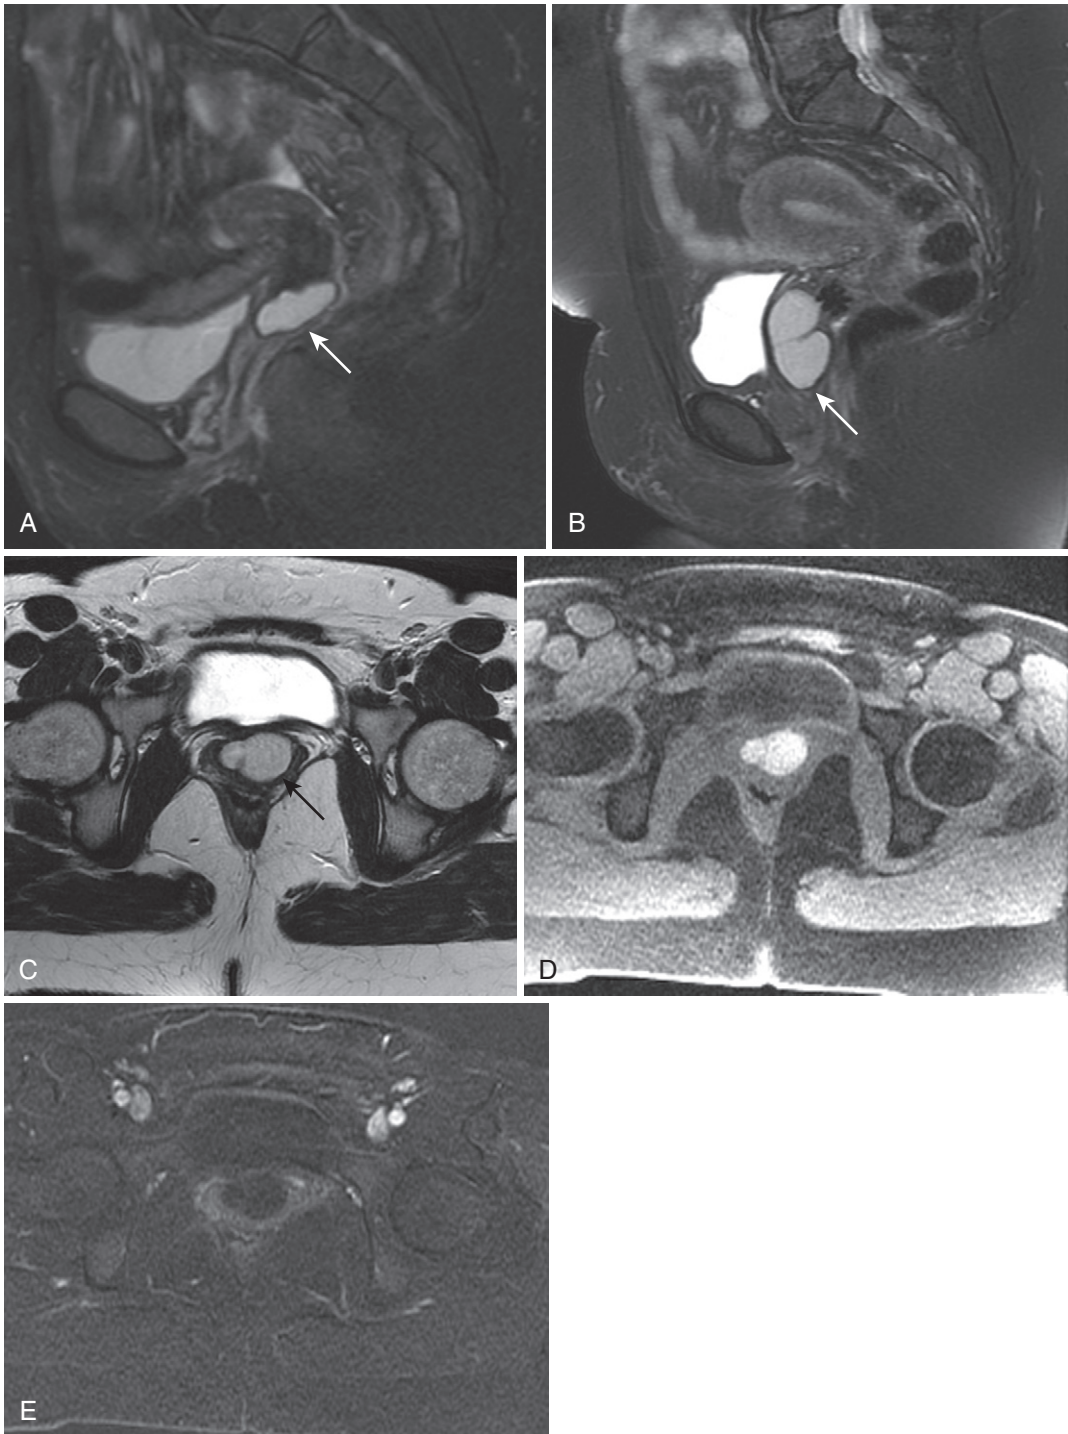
Müllerian duct cyst. The sagittal T2-weighted fat-suppressed image (A) demonstrates a large cystic lesion in the upper vagina (*arrow*). In a different patient (B), the sagittal fat-suppressed (B) and axial (C) images shows a large septated cystic lesion (*arrow*) also in the upper vagina. The fat-saturated T1-weighted image (D) demonstrates hyperintensity due to mucinous/proteinaceous content and the subtracted postcontrast image (E) confirms cystic nature with lack of enhancement.
